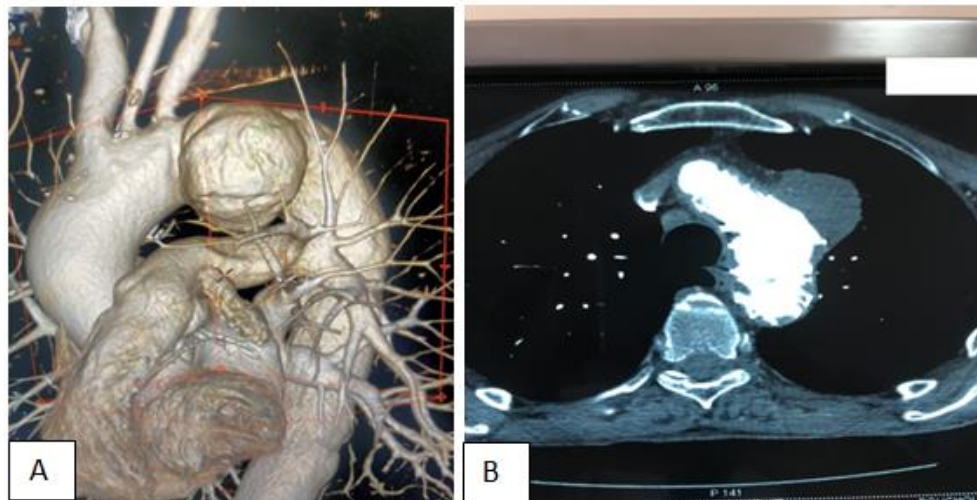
A: sagittal images of the thoracic aorta in 3D reconstruction Showing a pseudoaneurysm (arrowhead) in the aortic isthmus. B: Thoracic CT in axial incidence showing a pseudoaneurysm of the thoracic aorta at the level of the aortic isthmus
